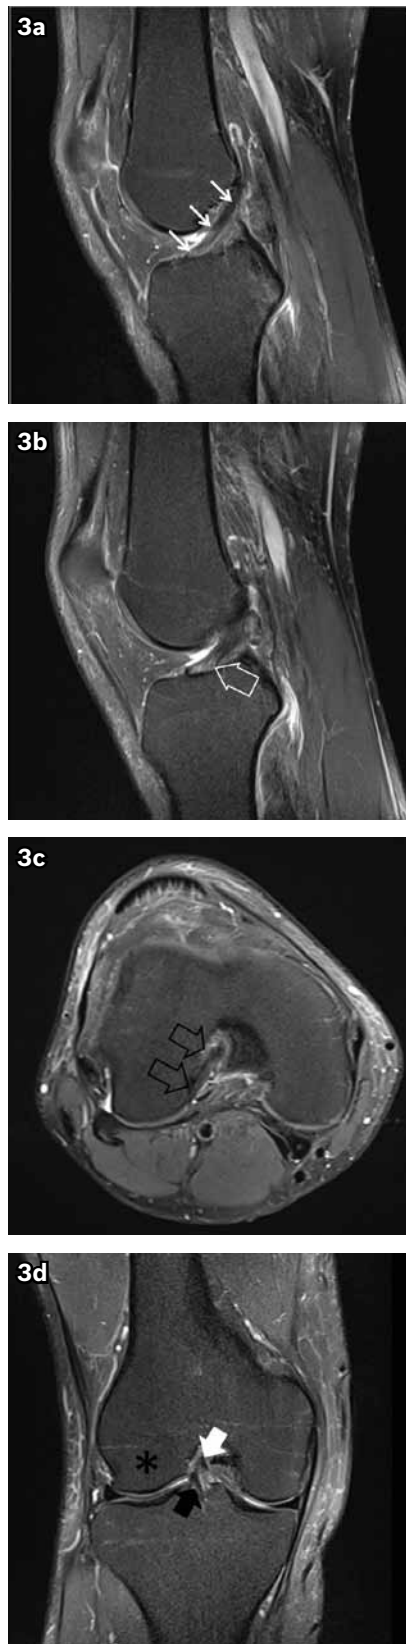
Normal ACL in a 21-year-old man. (a & b) Contiguous fat-suppressed sagittal PD-W MR images show a normal ACL, which appears as a taut, well-defined hypointense solid band (white arrows). Note the fan-like appearance of the distal ACL (posterolateral bundle) as it inserts onto the tibia (white open arrow). (c) Axial fat-suppressed MR image shows the ACL appearing as an elliptical hypointense band adjacent to the lateral wall of the intercondylar notch (black open arrows). (d) Fat-suppressed coronal MR image shows the ACL appearing as a hypointense structure close to the medial aspect of the lateral femoral condyle (*). Note the anteromedial bundle (white solid arrow) and posterolateral bundle (black solid arrow).
